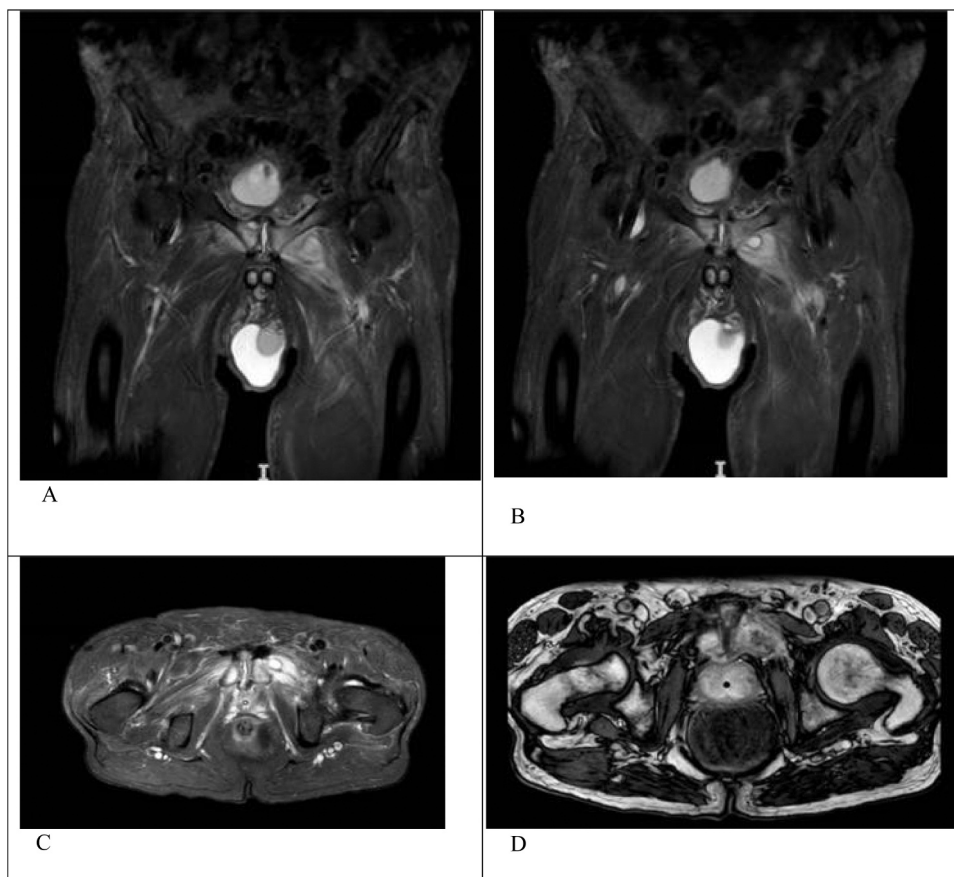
A. Subchondral abscess on a coronal section MRI. B. Abscessed collection of the left obturator muscle on a coronal section MRI. C. Abscesses on an axial section on T2 MRI. D. Abscesses on an axial section on T1 MRI.
